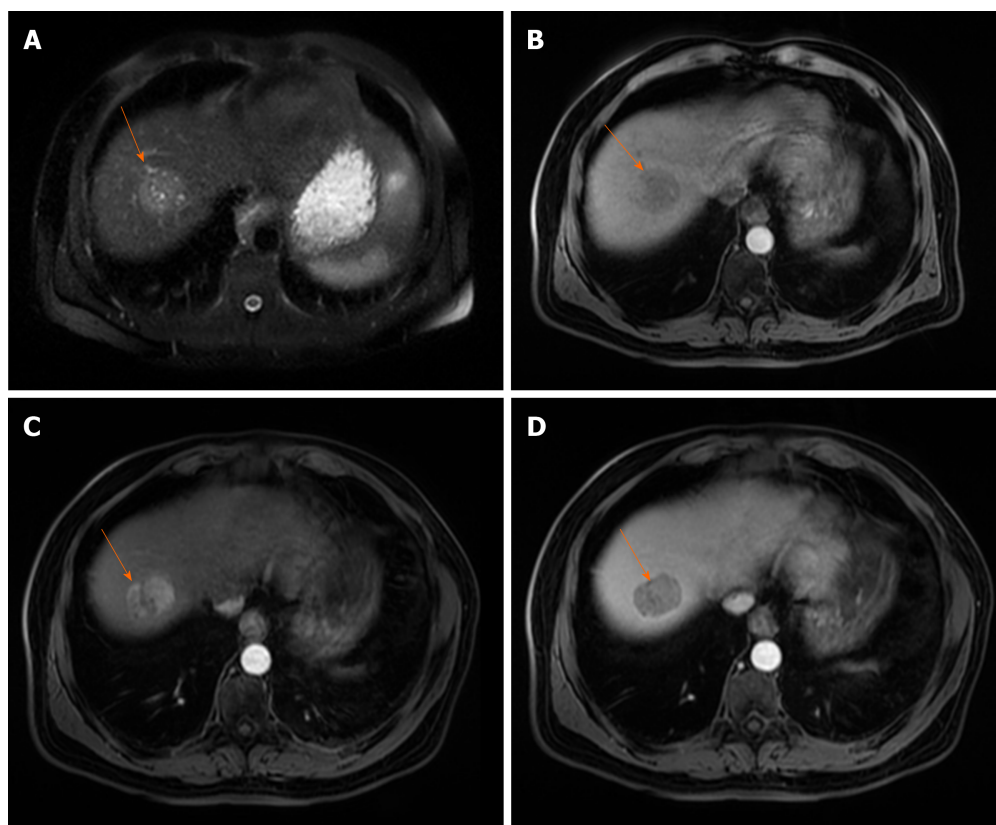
Typical hepatocellular carcinoma in 68-year old man with cirrhosis. A: On axial T2-weighted image a nodular heterogeneously hyperintense tumor (arrow) is seen; B-D: The lesion (arrow) is hypointense on T1-weighted image (B), hypervascular on arterial phase (C) with washout in portal venous phase (D).
